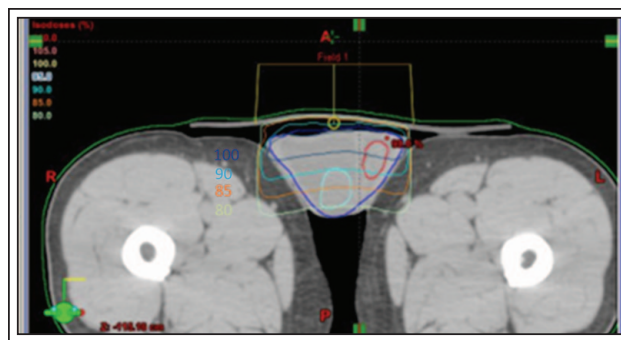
CT scan of a patient showing the isodose distribution to the scrotum with a direct 6 MV field.
